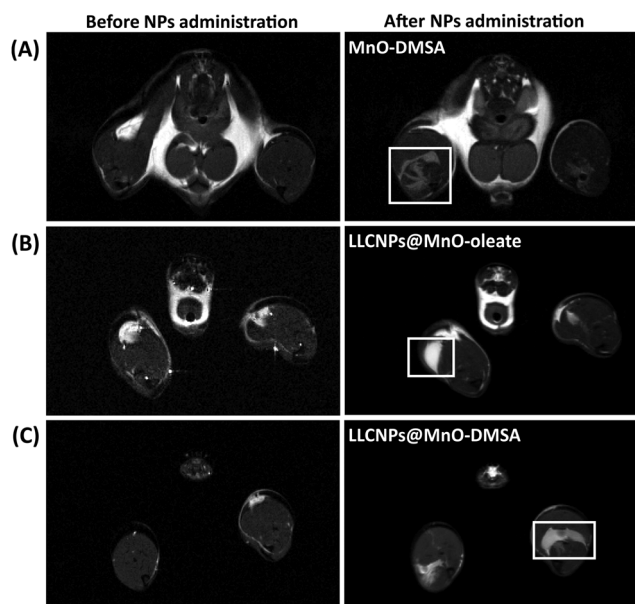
In vivo* T_1 -weighted MR images before (left column) and after administration (right column) of (A) MnO-DMSA, (B) LLCNPs@MnO-oleate, and (C) LLCNPs@MnO-DMSA. The images were collected using a 9.4 T horizontal MRI scanner, at 37 °C. Regions of hind limbs are marked with a white square with an enhanced contrast by administered NPs as contrast agents.
